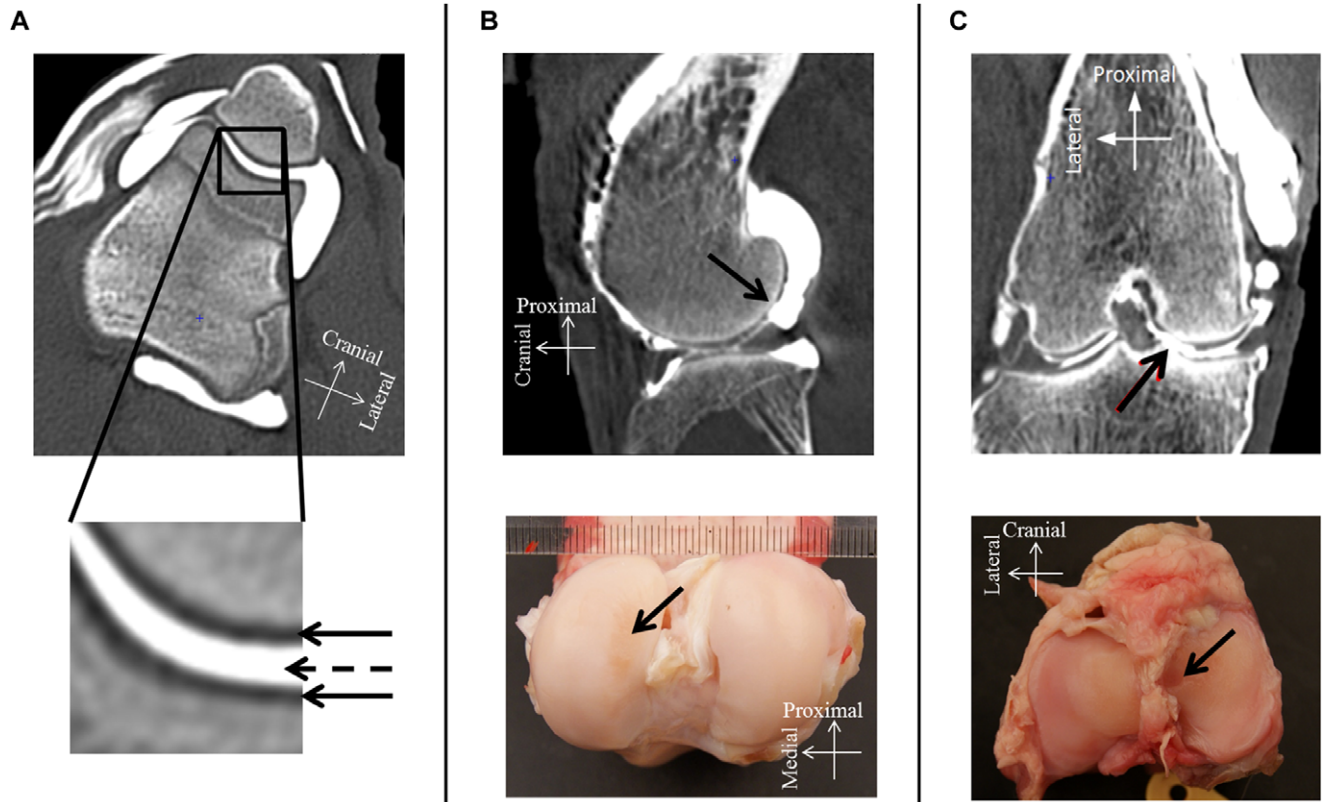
Appearance of cartilage in CTA images. (A) Intact cartilage appears as a sharp radiolucent layer (plain arrows) underlined by the radiopaque contrast medium (dotted arrow). (B and C) Examples of cartilage defects. (B) A score-2 defect on the medial femoral condyle; (C) a score-3 defect on the axial aspect of the medial tibial condyle. [Color figure can be viewed at wileyonlinelibrary.com]
